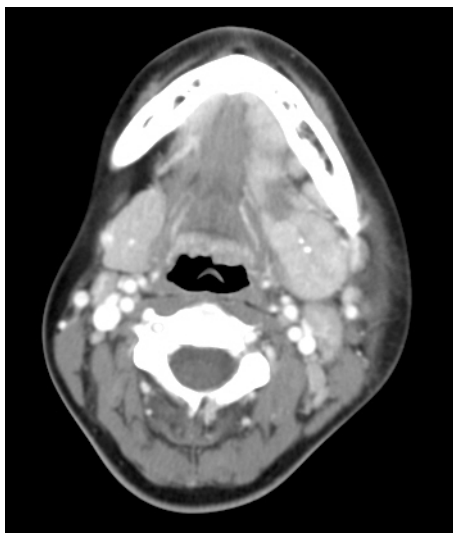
Bilateral parotid sialadenitis in a 3 year-old boy. Postcontrast CT scan shows homogenous enhancement in bilateral parotid glands. It also shows no abscess associated.
